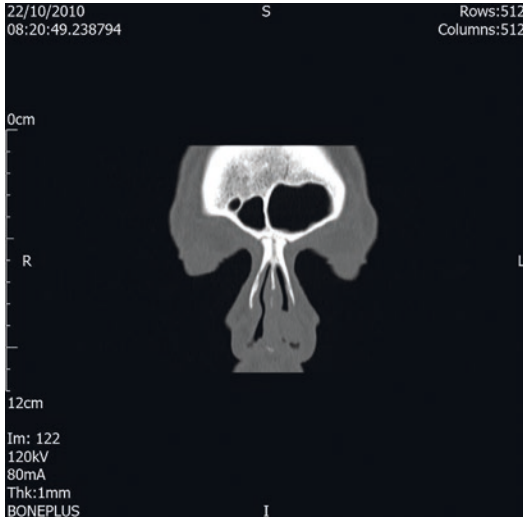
Coronal CT scan of the paranasal sinuses demonstrating a soft tissue lesion arising from the left side of the nasal septum
